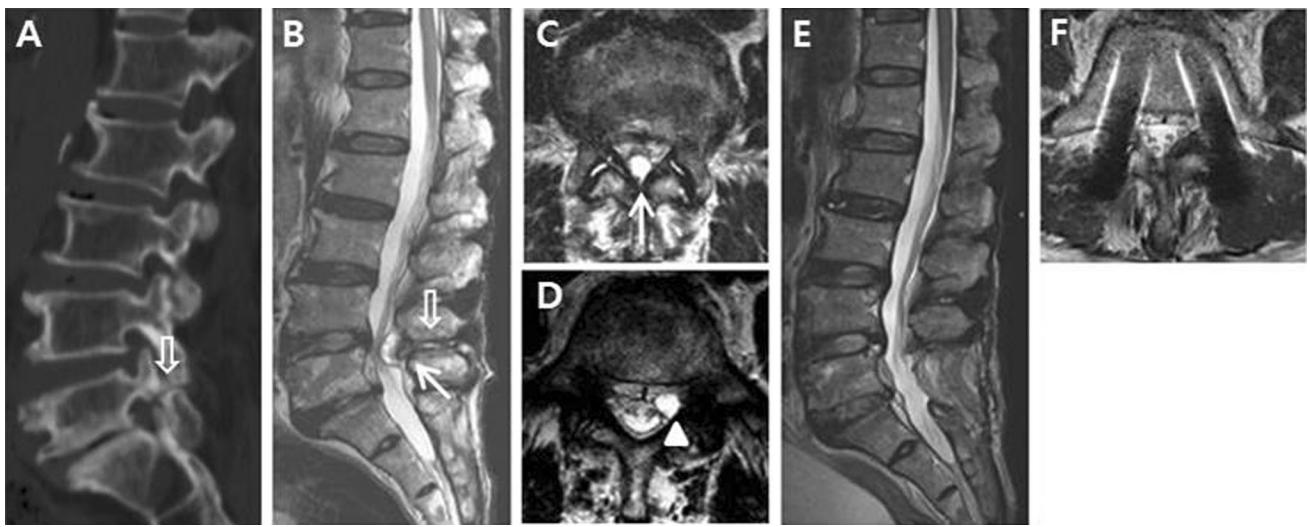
a Computed tomography (CT) image showing spondylolytic spondylolisthesis (*empty arrow*). MRI confirmed b, c an interspinous bursitis (*empty arrow*) and a large central posterior epidural cyst causing spinal stenosis (*arrow*). d A subarticular facet synovial cyst
